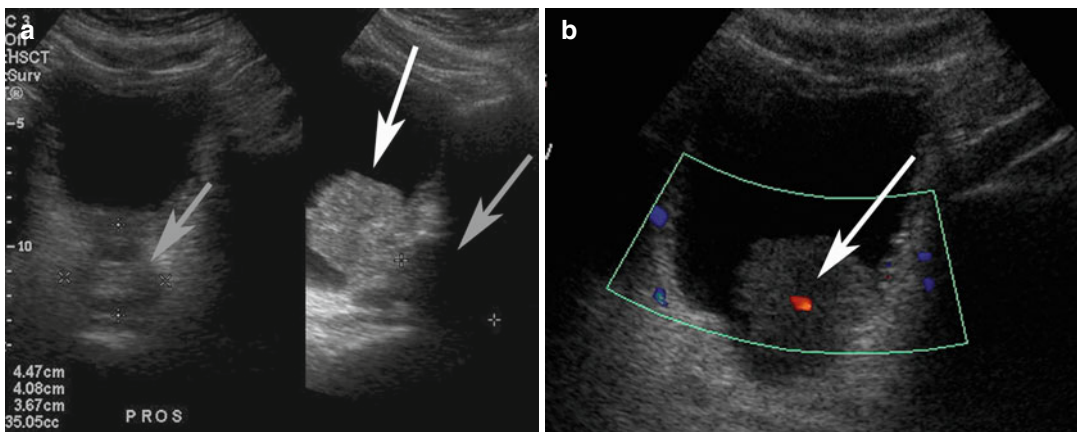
(a) Transverse (*left*) and sagittal (*right*) ultrasound images of the bladder in a patient with a midline soft tissue mass. The prostate is depicted in the left image and the mass appears to be of different echogenicity than
